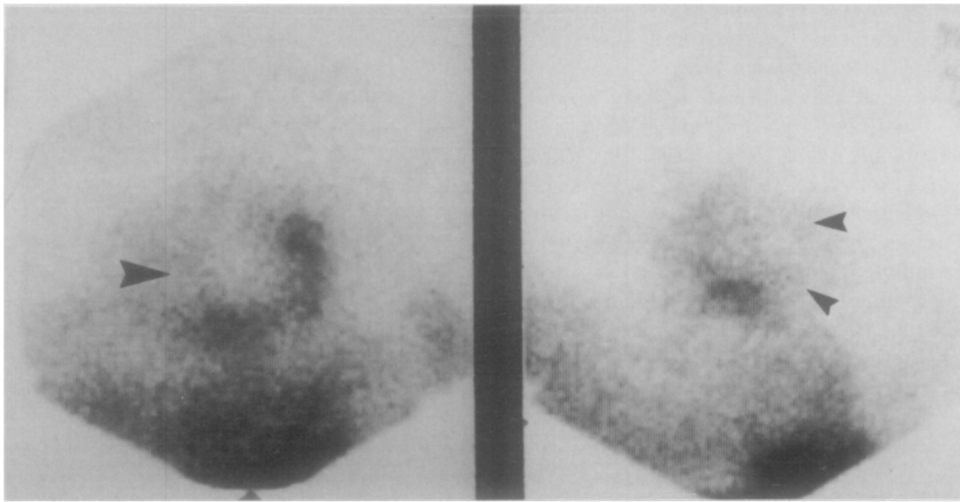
Rest thallium myocardial perfusion scintigram in the anterior (*right*) and 40-degree left anterior oblique (*left*) projections. There is marked decreased tracer uptake in the septal and apical segments (*arrow, left panel*), with less severe perfusion defects in the anterior and apicoinferior portions of the left ventricle (*arrows, right panel*).
